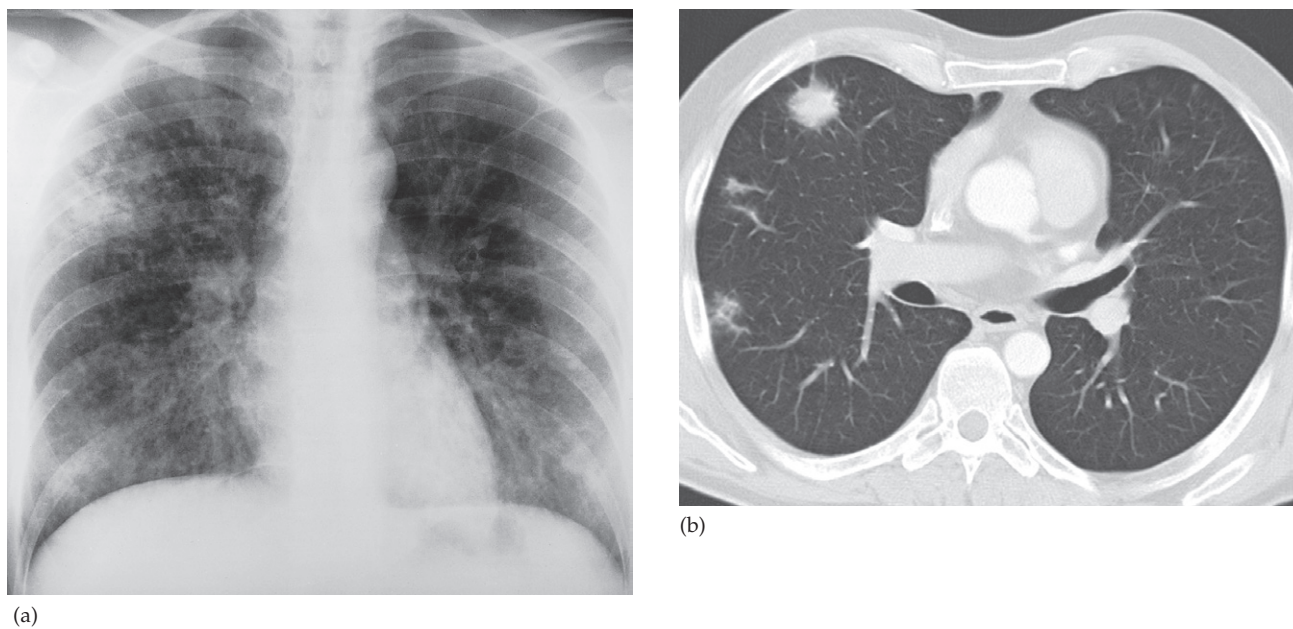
(a) Lymphoma involving the lung. The extensive pulmonary consolidations were due to neoplastic involvement. Pneumonia can give a similar appearance. (b) CT in a patient with primary pulmonary lymphoma showing more nodular opacities.
